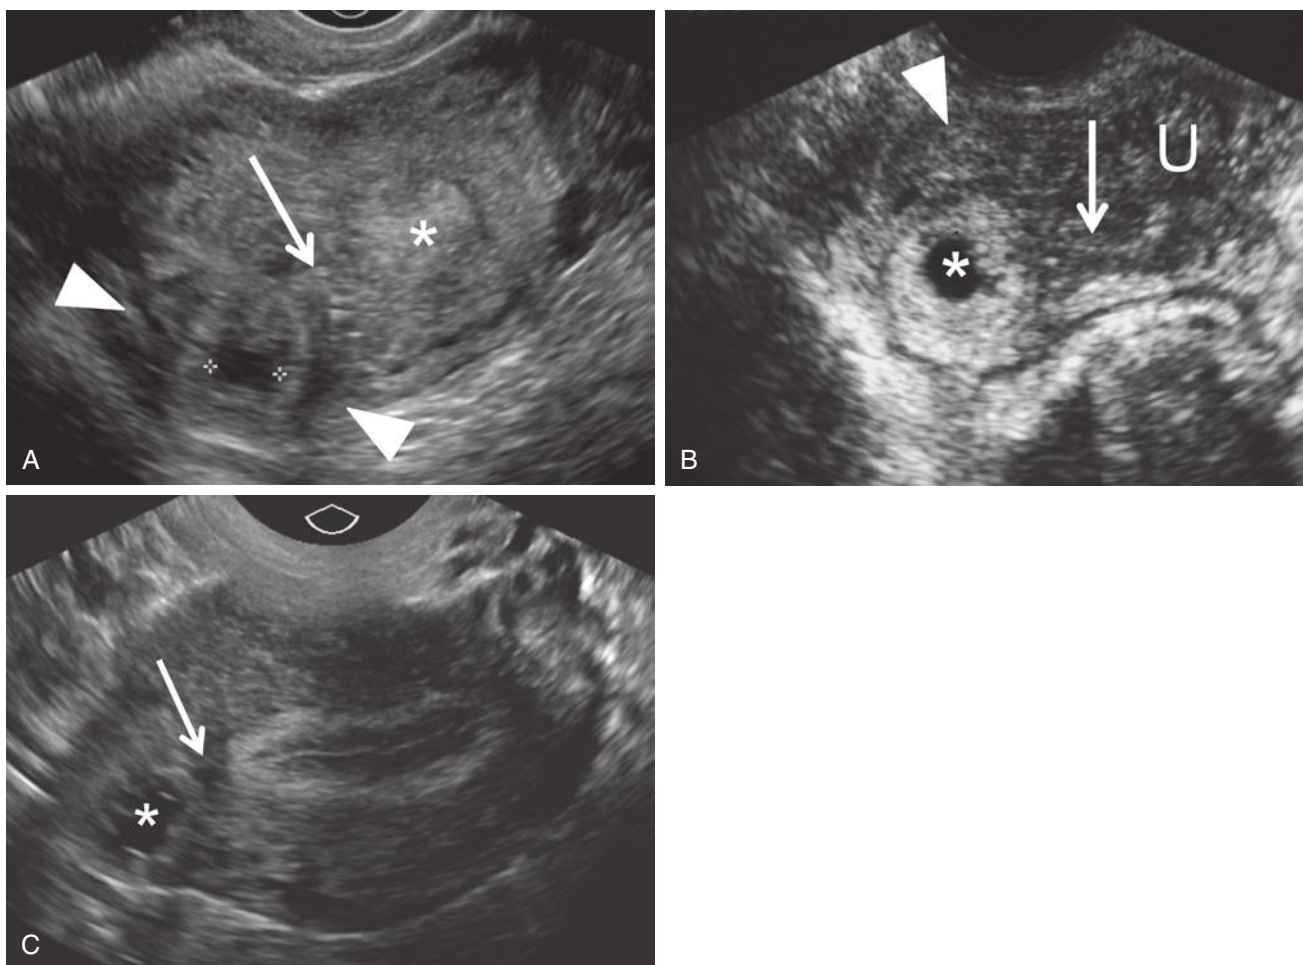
Interstitial ectopic pregnancies. A, Transvaginal transverse scan of the uterus shows the eccentrically located interstitial ectopic pregnancy (*calipers*) separate from the endometrial cavity (*asterisk*). Myometrium (*arrow*) clearly separates the medial edge of the gestational sac from the echogenic endometrium (*asterisk*) and surrounds the sac (*arrowheads*). B, Transvaginal transverse scan of the uterus (U) in another patient demonstrates the interstitial line sign, a thin echogenic line (*arrow*) extending from the endometrium toward the right-sided interstitial ectopic pregnancy (*asterisk*). Note that the myometrium (*arrowhead*) partially surrounds the gestational sac. C, Transvaginal transverse scan of the uterus in a third patient with right-sided interstitial ectopic pregnancy (*asterisk*) demonstrates myometrial tissue (*arrow*) intervening between the edge of the gestational sac and the echogenic endometrium. (A, Courtesy Department of Obstetrics and Gynecology, Yale University School of Medicine, New Haven, CT.)
